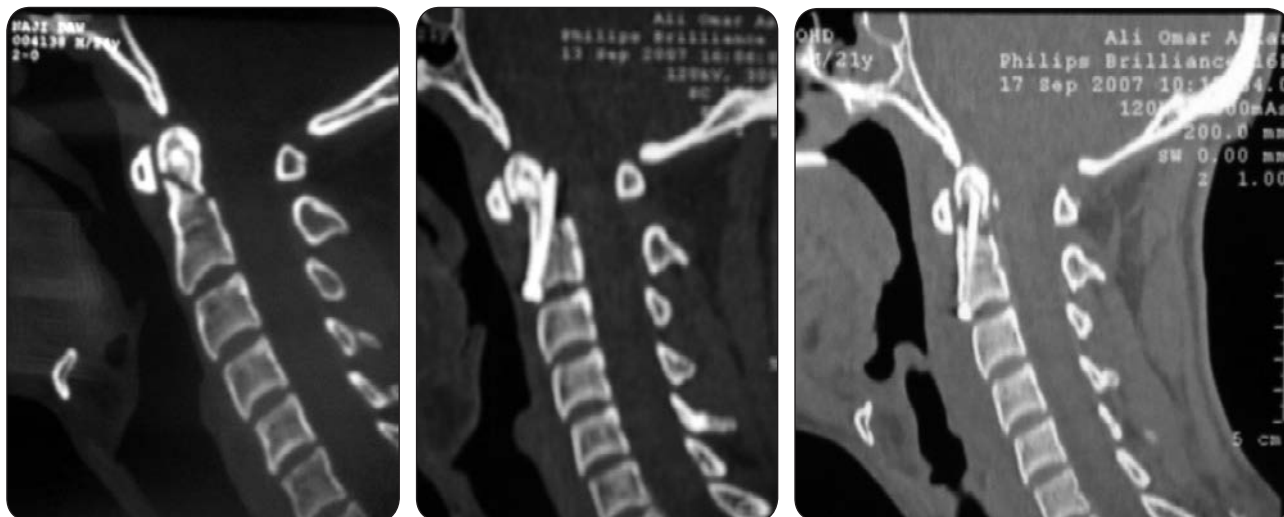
ND, 25 year old male sustained a type-II Odontoid fracture. Postoperative CT shows a posteriorly misplaced screw. Revision screw fixation was successfully done. Note the distraction at the fracture site. He went on to a stable fibrous union.
